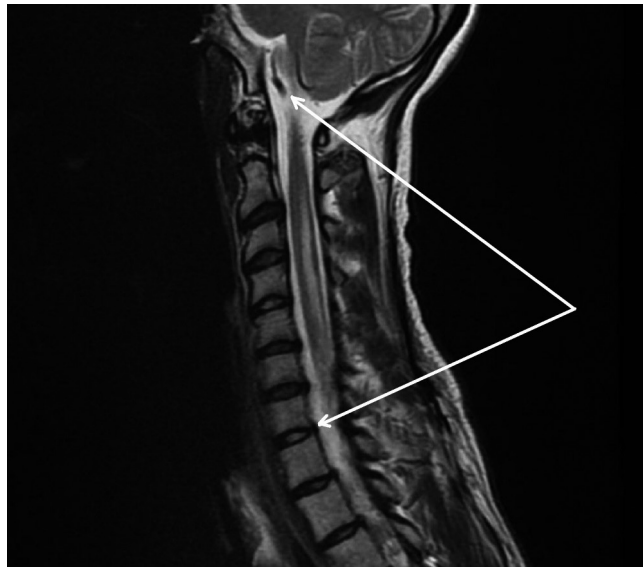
Sagittal spinal cord magnetic resonance imaging: T2-hyperintense lesion extending from the medulla throughout the cervical spinal cord (white arrows) to the T10 level.
